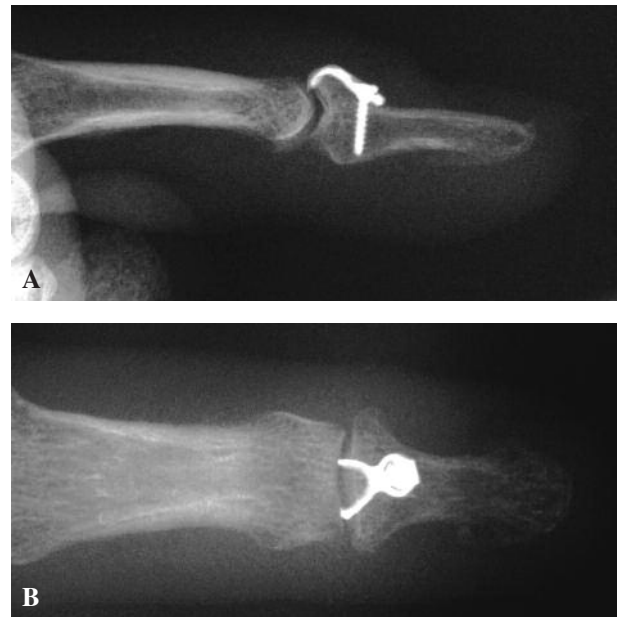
Lateral (A) and anterior-posterior (B) radiographs 7 weeks after surgery showing fracture union and hook plate *in situ*.
